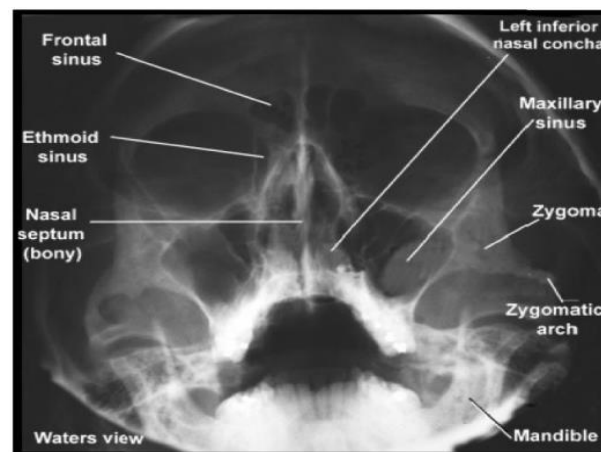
radiographic appearance of Water's view x-ray
